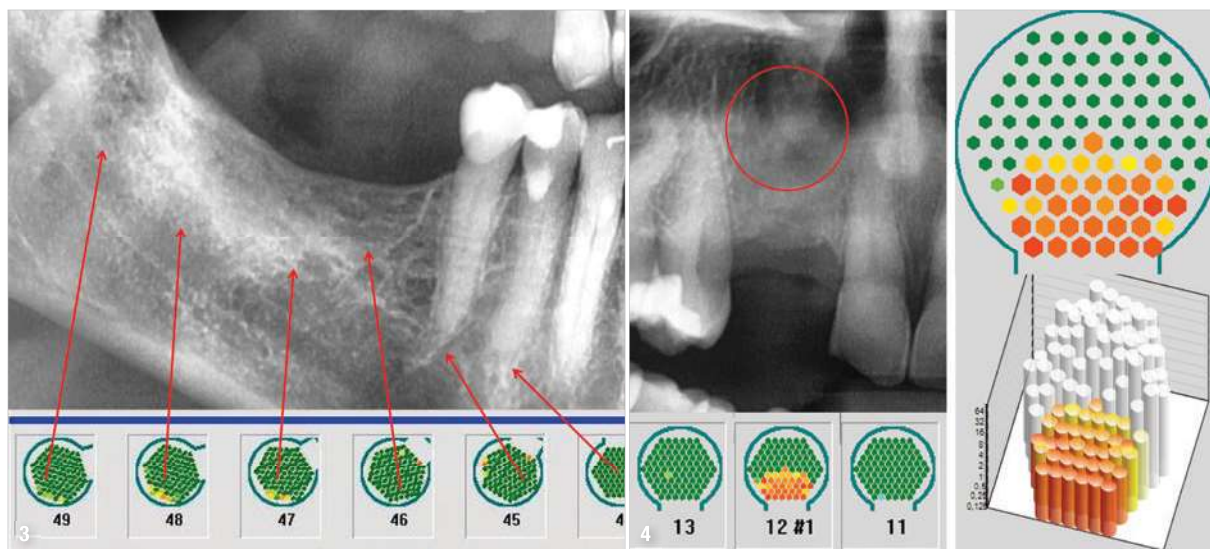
Good example of a perfect state of mineralisation in a lower jawbone, which is characterised by widespread green colouration in CaviTAU® and is suitable for a prospectively unproblematic insertion of implants. This finding is consistent with good conditions for a long implant lifetime. Fig. 4: Example of an inconspicuous radiographic image in area #12 (red circle). In contrast, measurement of bone density in area #38 compared with healthy neighbouring teeth #13 and 11 (below left) with ultrasound shows conspicuous red areas in 2D and 3D representation (right).
